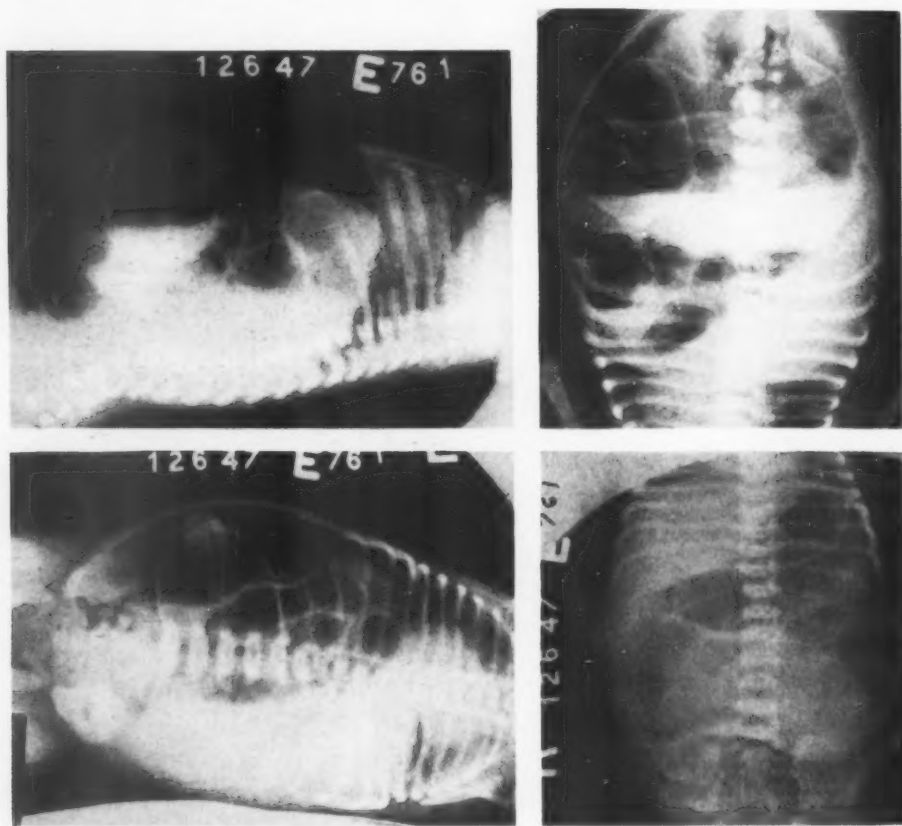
Case 17. Ileal atresia with perforation. Plain roentgenograms in four different positions show multiple distended and gas-filled loops of small intestine, fluid levels within the loops and also free in the peritoneal cavity, and pneumoperitoneum.
